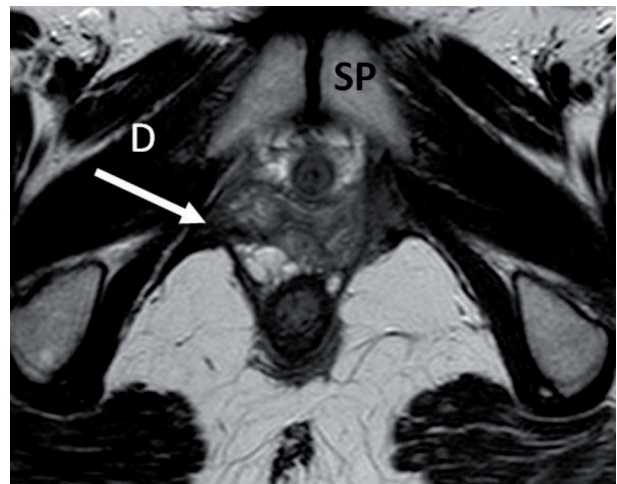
Axial T2-weighted view at rest of the levator hiatus for imaging of urethra, vaginal and paravaginal supports, and anal canal. SP = symphysis pubis; D = defect of pubococcygeus muscle and posterior paravaginal attachment (arrow).
